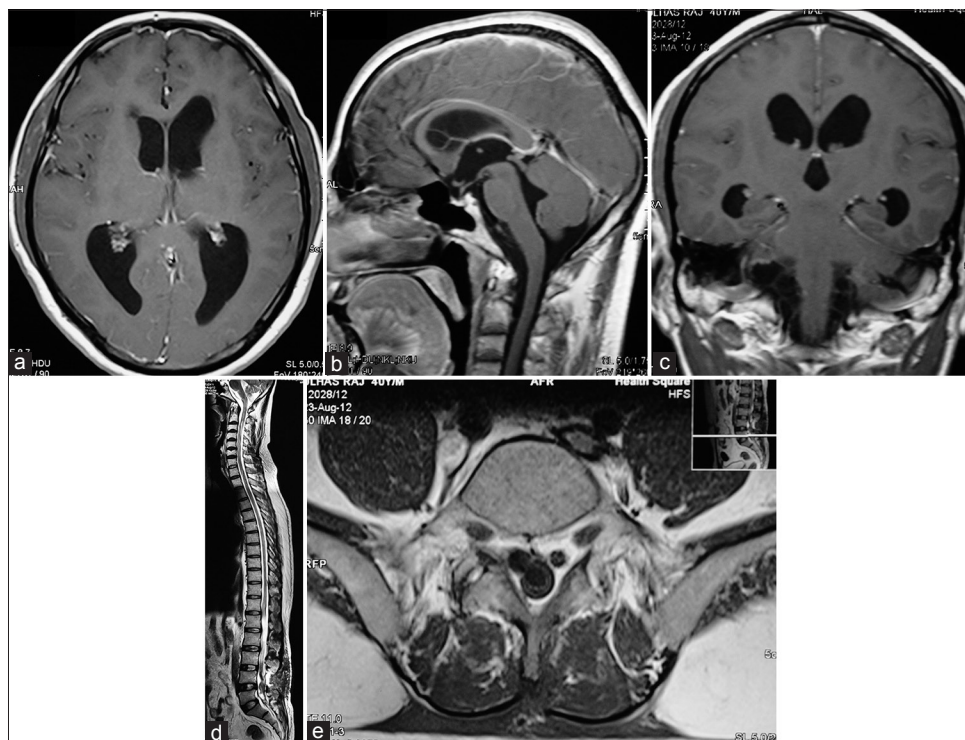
Contrast magnetic resonance imaging of brain showing no intracranial lesion (a-c), Postoperative T2-weighted sagittal image (d) and axial contrast T1-weighted image (e) Complete excision of lesion at L5 level with no evidence of concurrent lesion on screening of whole spine
